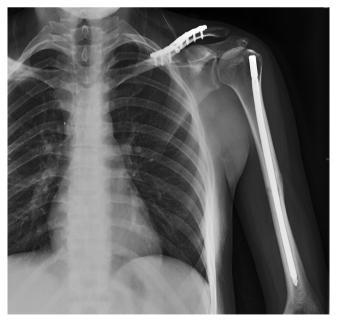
Radiograph at post-operative month 15 in a patient with clavicle fracture accompanied by humerus shaft fracture.
